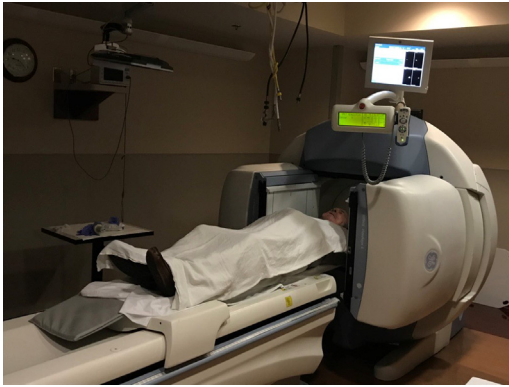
SPECT-CT scanner with patient in position. Imaging duration can vary based on tracer drainage into the SN. Drainage pattern is visualized on the monitor above the scanner.
